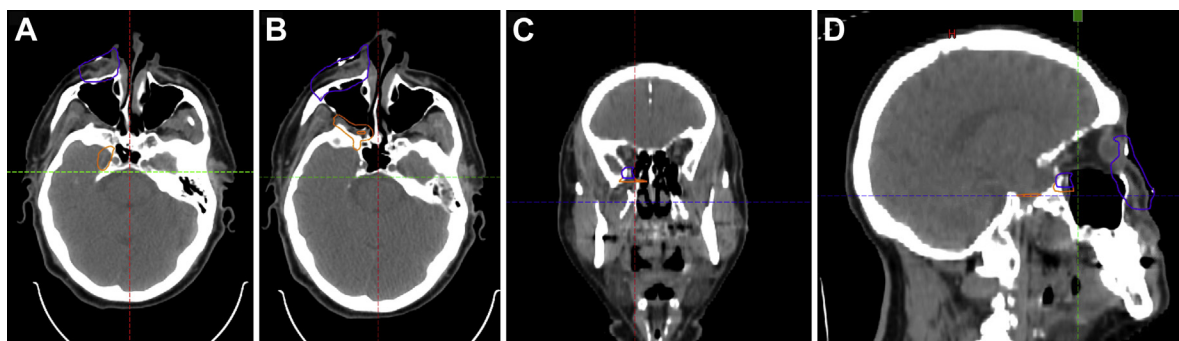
Clinical target volume (CTV) delineated by a radiation oncologist (RO) (blue) and with modifications by a neuro-radiologist (NR)/otolaryngologist (OL) (orange) on axial (A,B), coronal (C), and sagittal (D) computed tomography (CT) images.
